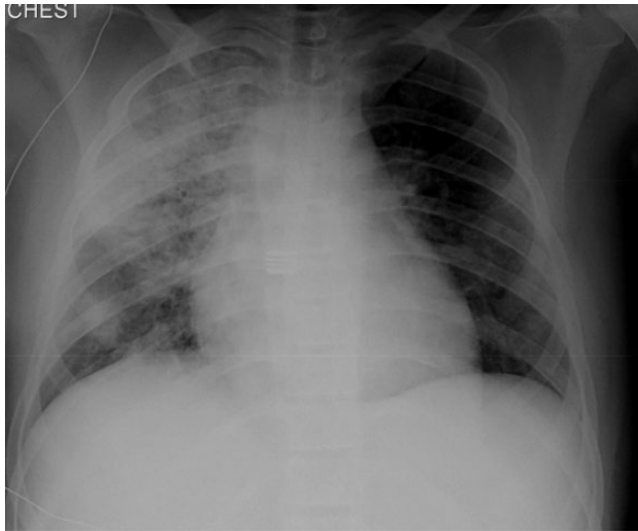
Chest X-ray of a teenage girl with *Mycoplasma pneumoniae* pneumonia.
